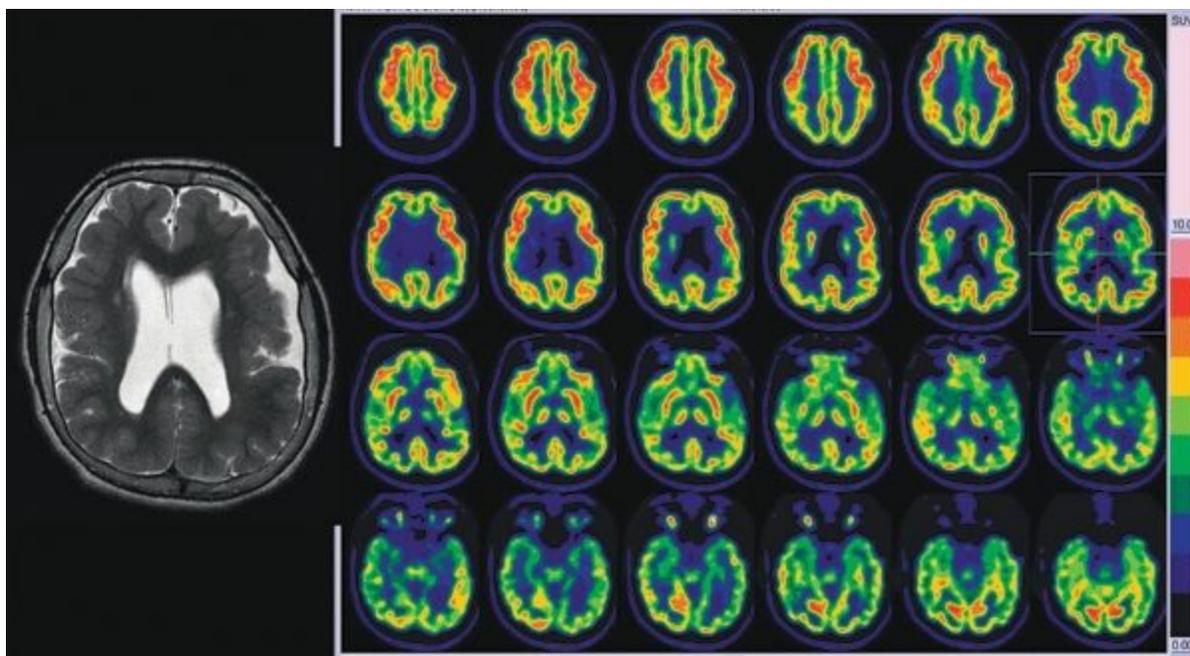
Brain MRI Axial T2 image and PET scan of Case 4. MRI shows bilateral polymicrogyria. PET scan shows bilateral extensive and multilobar hypometabolism. Case 4 is a 16-year-old right-handed male with seizure onset at age 7 months. His seizures are axial spasms, myoclonic seizures, and atypical absence seizures. He has multiple seizures daily. On examination, he has clinic features consistent with moderate cognitive impairment and spastic quadriplegia with lower extremity predominance. Current
